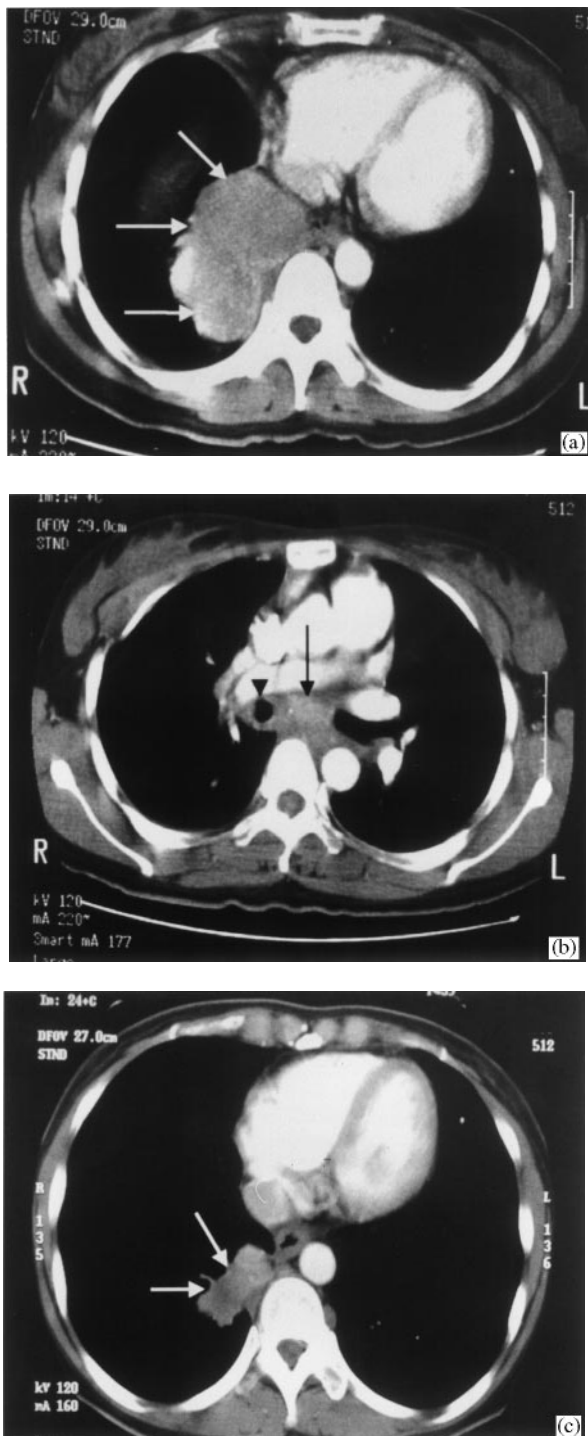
Thoracic computed tomography (CT) of one of the patients showing (a) a $2 \times 2 \times 5 \text{ cm}^3$ lower lobe tumour and (b) mediastinal lymphadenopathy (arrow) before treatment with 5-fluorouracil, leucovorin and cisplatin; and (c) the reduction in tumour bulk after chemotherapy.
